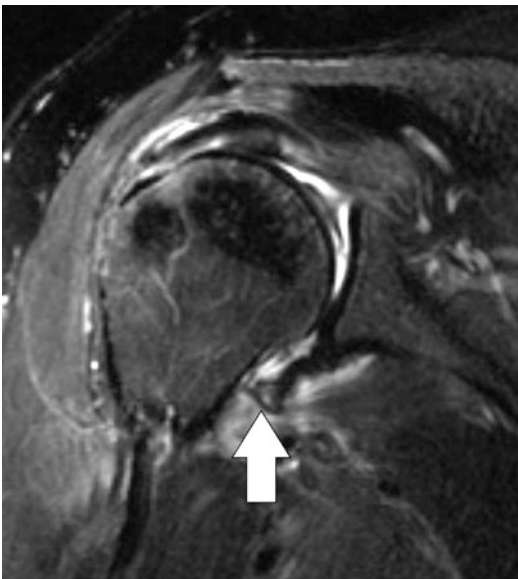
Bony humeral avulsion of the glenohumeral ligament (BHAGL) lesion. Coronal T2-weighted MR image shows an avulsed fragment of bone (arrow) arising from the humeral attachment of the anterior band of the inferior glenohumeral ligament. This lesion may mimic an osseous Bankart lesion on radiographs
